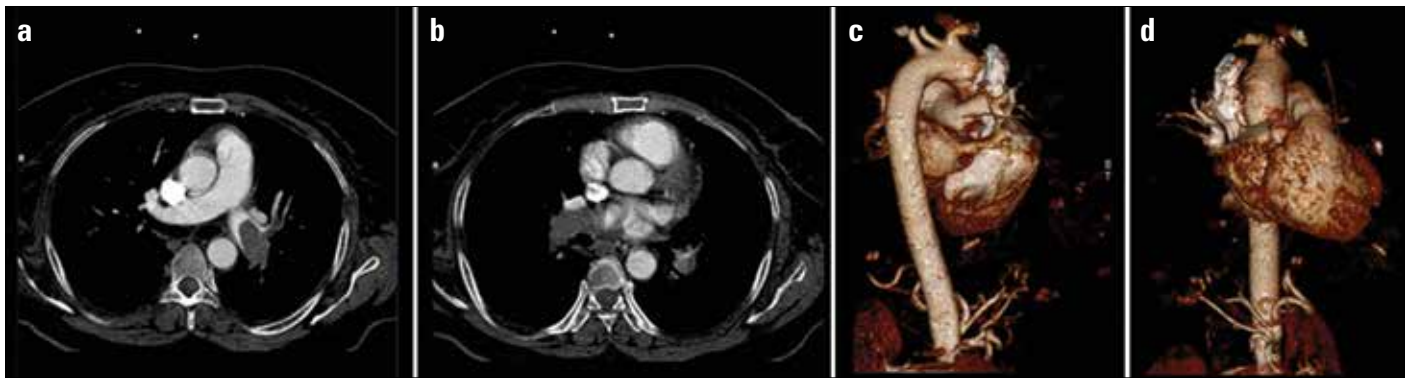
a-d. CT angiography and 3D images of intraluminal filling defect in the left (a, c) and right (b, d) main pulmonary arteries, extending into lobar branches
